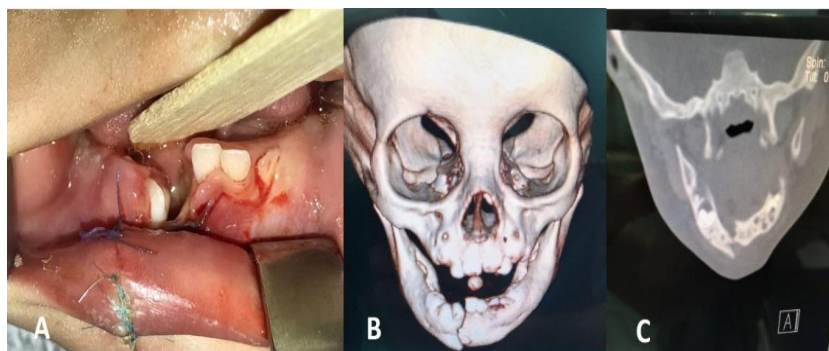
A-C. Preoperative Clinical and Radiographic View of Right Mandibular Parasymphysis Fracture with Significant Displacement
